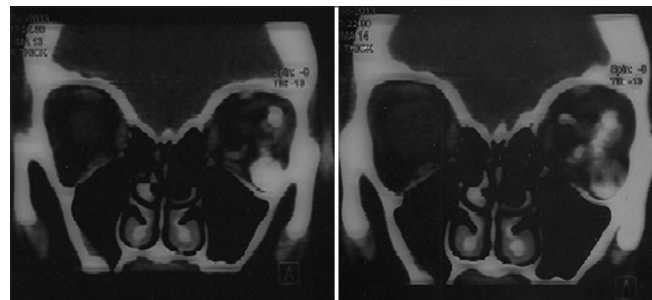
Orbital computed tomography scan, axial incidence, shows an 11 mm × 8 mm soft tissue mass in lateral aspect of the left orbit
